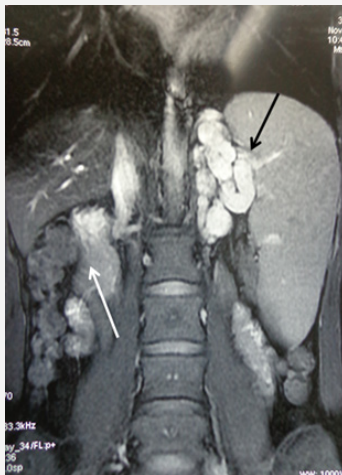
Coronal T1-weighted abdominal MRI with gadolinium: Portal Cavernoma (white arrow) and splenomegaly with very marked splenorenal collateral circulation (black arrow).
